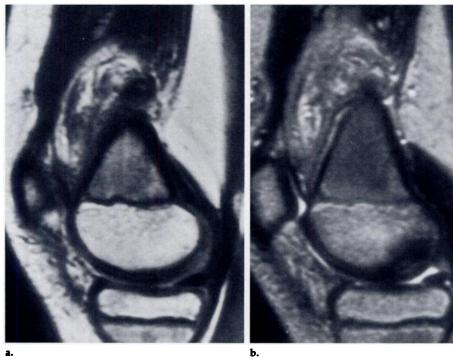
Sagittal MR images of the knee show a 7-cm suprapatellar hemangioma in an 11-year-old boy. The mass is centered in the prefemoral fat but is infiltrating into the quadriceps. (a) On this SE 2,300/20 image, vessels are difficult to identify. (b) On this T2-weighted image (SE, 2,300/80), the hemangioma has a malignant appearance, with infiltrating, irregular margins and inhomogeneous signal intensity.
